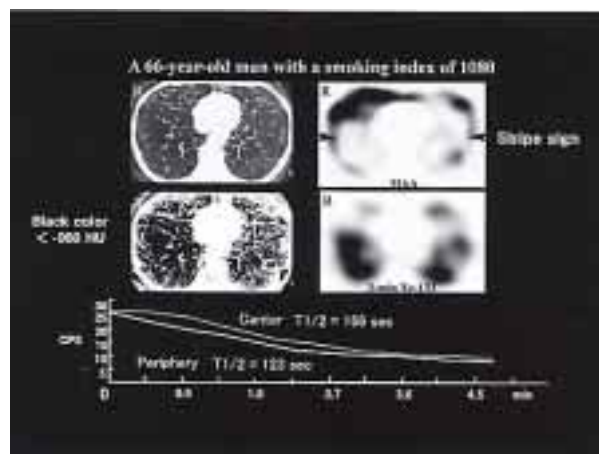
A 66-year-old man with a smoking index of 1080. A chest CT scan (top, left) shows emphysematous and/or bullous changes predominantly in the central lungs. The density mask CT image (middle, left), which specifically visualizes the low attenuation lung area (LAA) with lung attenuation values of -960 Hounsfield units (HU) as a monotonous black color, shows central-dominant LAA distributions. ^{99m}Tc-MAA SPECT (top, right) shows periphery-dominant perfusion with central perfusion defects in both lungs. A ¹³³Xe SPECT image 3 min after initiation of washout (middle, right) shows ¹³³Xe retention mainly in the central lung area. The time-activity curves in the right lung (bottom) show a more prolonged T_{1/2} in the central lung area than in the peripheral lung area.
